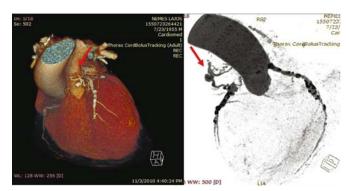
Three-dimensional multislice computed tomographic image showing a coronary fistula using VRT (A) and angiographic view (B)
